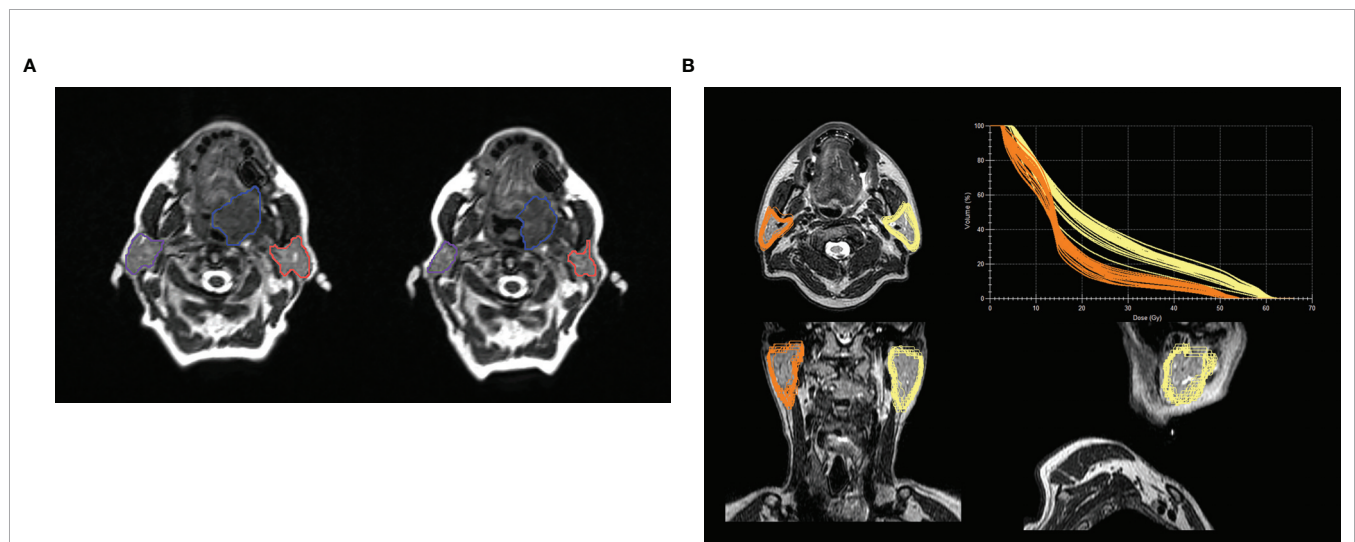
(A) Example of volume changes and migration of parotid glands during the course of fractionated radiotherapy at an 0.35 T MR-Linac or a large base of tongue carcinoma between treatment start (left image) and beginning of the 7th treatment week - boost (right image). Left and right parotid glands are delineated in orange and violet respectively and the gross tumor volume in blue. The volume of the left and right parotid glands decreased by 8.2 cc and 10.0 cc, respectively. The inter-parotids distance changed from 11.0 cm to 10.3 cm. (B) Example of a post treatment analysis for a patient treated for a hypopharyngeal carcinoma with 70 Gy in 35 fractions. Parotid glands were contoured for each daily MRI during the course of fractionated radiotherapy at a 1.5 T MR-Linac and propagated to the T2w planning MRI, with the total plan DVH for each daily delivered plan in the upper right corner, showing the variance in actual delivered dose depending on volume of the parotid gland. Averaged D_{mean} of the anatomically corrected and daily adapted plans was 24.4 Gy and 16.5 Gy for the left and right parotid glands, respectively. The D_{mean} of the reference plan was 25.9 Gy for the left and 16.7 Gy for the right parotid gland. Baseline volume was 31.0 ccm for the right and 34.5 ccm for the left parotid gland. Mean volume (range) during treatment was 30.3 ccm (29.5–32.1) and 31.4 ccm (29.1–34.7). The example was presented as a poster at the congresses of DEGRO and AIRO 2019 by Monica Io Russo, MD (20).
